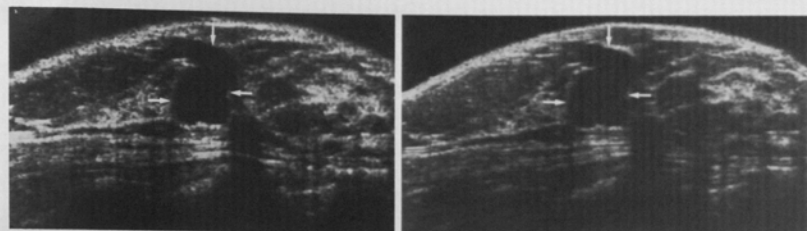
Longitudinal 4-MHz (a) and 7.5-MHz (b) sonograms of a 2-cm lobulated cyst (arrows) lateral to the right nipple. Although the image quality is improved with the higher frequency transducer, there is no additional diagnostic information present on the 7.5-MHz scan.
